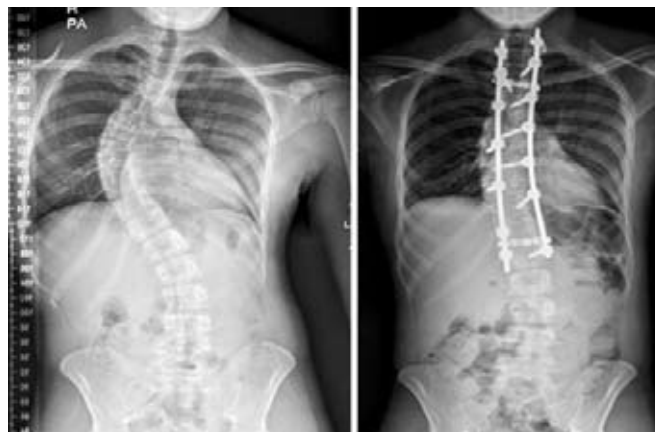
Pre- and post-operative spinal X-rays with correction of the scoliosis
